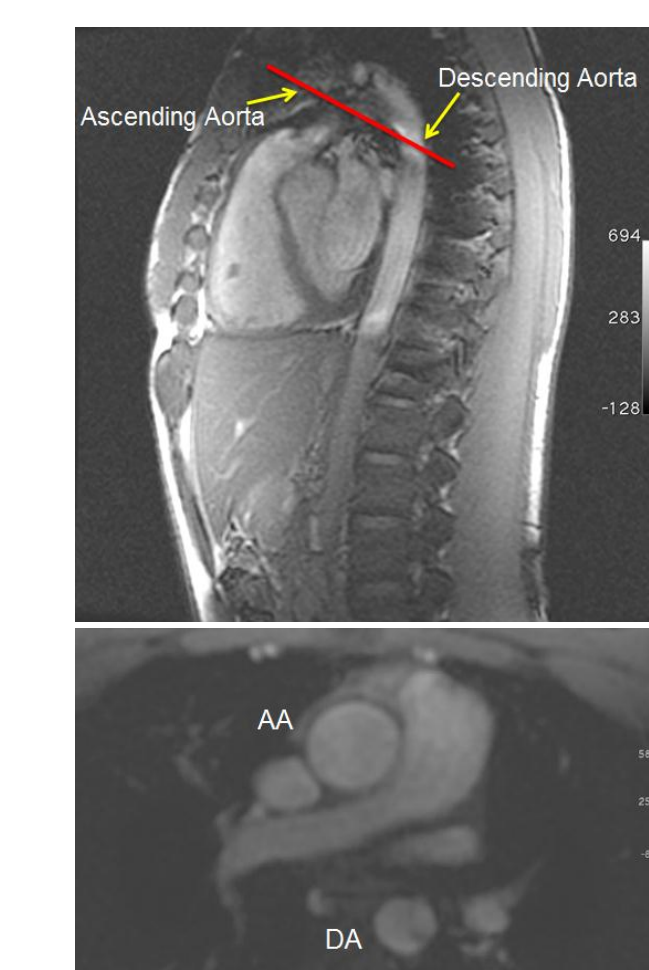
(left): MR images of ascending and descending aorta
